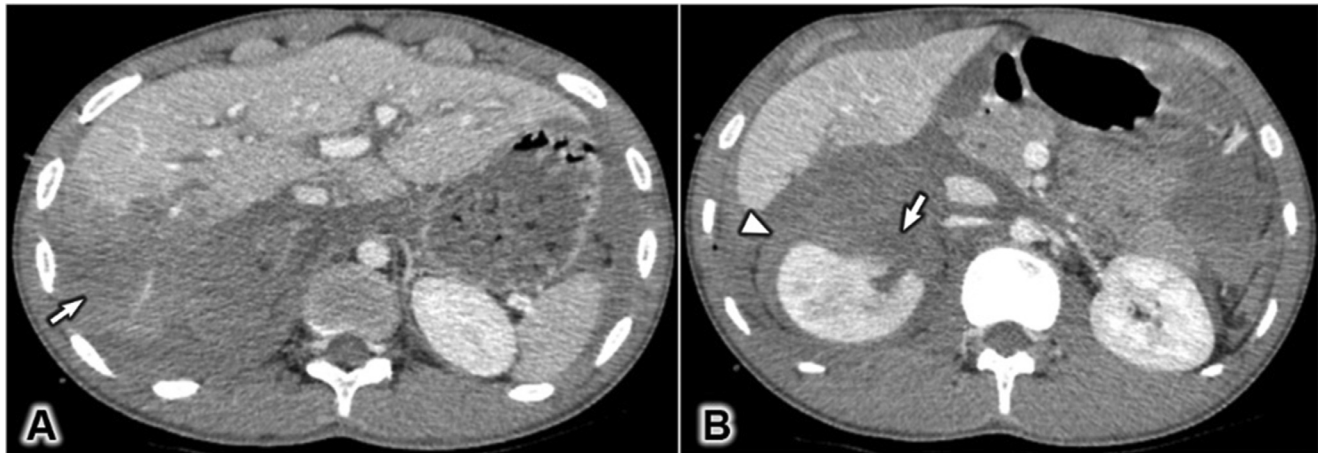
Intraparenchymal hematoma. (A) An axial CT scan of the abdomen in the portal venous phase showed a large intraparenchymal hematoma in the right hepatic lobe (arrow). (B) An axial view in the portal venous phase contrast-enhanced CT scan shows a renal laceration that does not involve the collecting system of the right kidney (arrow). A large perinephric hematoma surrounds the kidney (arrowhead).
